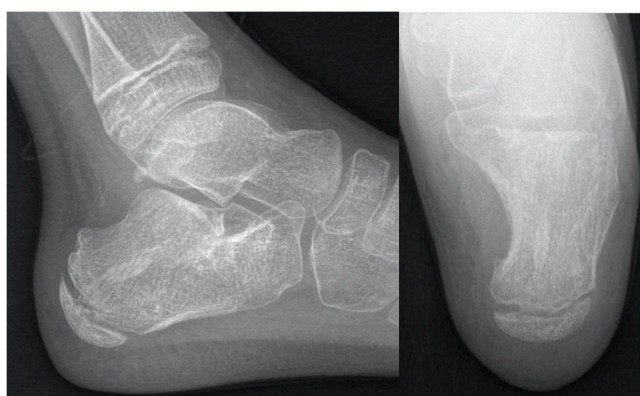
Simple radiography after more than 12 months of follow-up.
